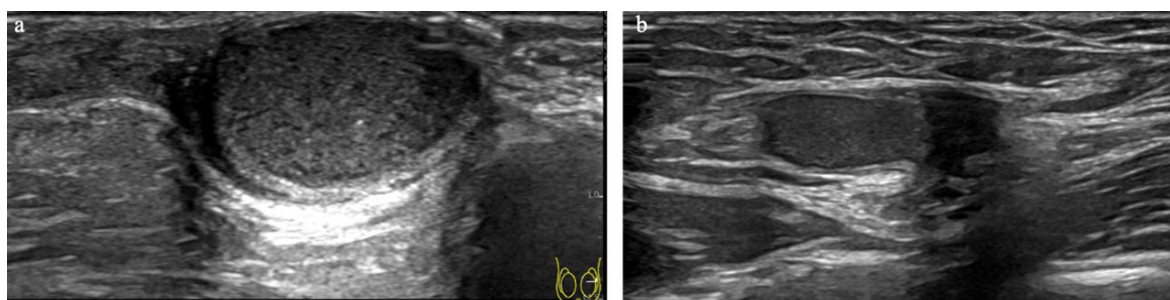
Sonogram shows a heterogeneous hypoechoic lesion (image a) in the left hemiscrotum surrounded by echogenic rim, and posterior acoustic enhancement, and a displaced left testis in the inguinal canal (image b).
